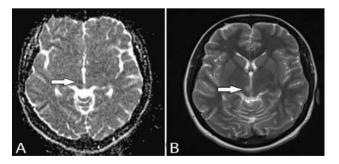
An MRI of the brain showing: A) hypo-intense lesion in apparent diffusion coefficient; and B) hyper-intense lesion in T2 weighted imaging at the site of right medial thalamus.
